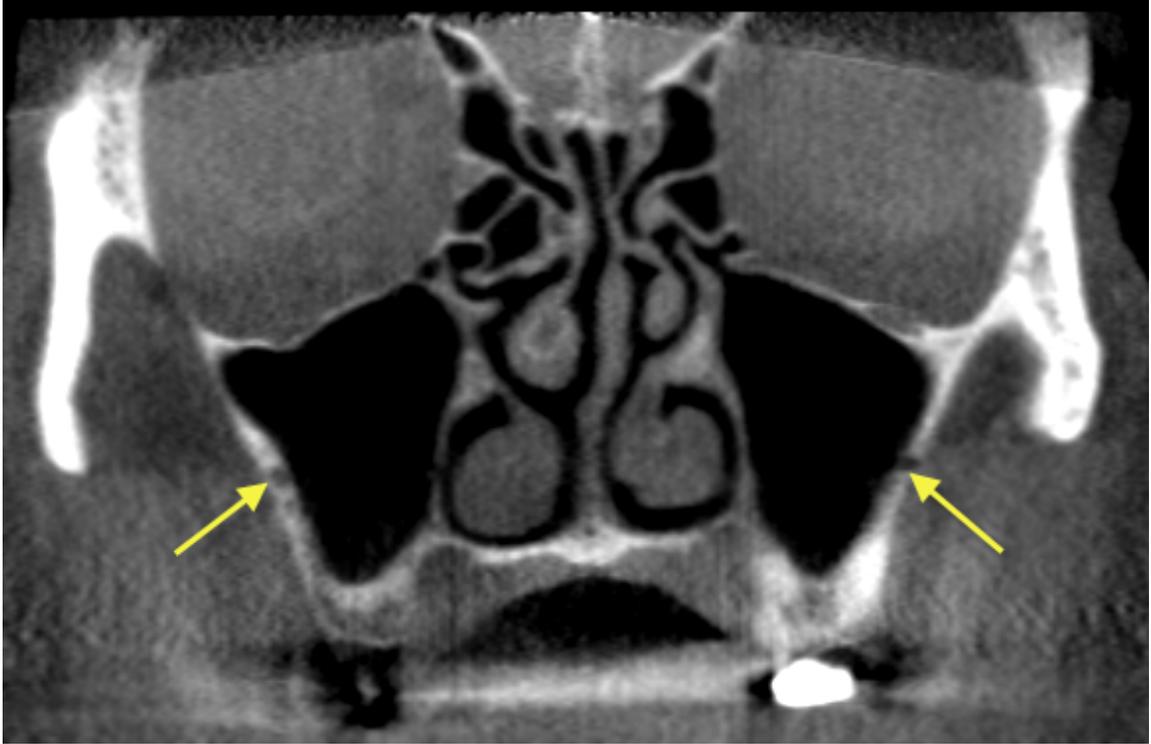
CBCT coronal section showing soft tissue thickening of sinusitis bilaterally (arrows) in the maxillary sinuses
